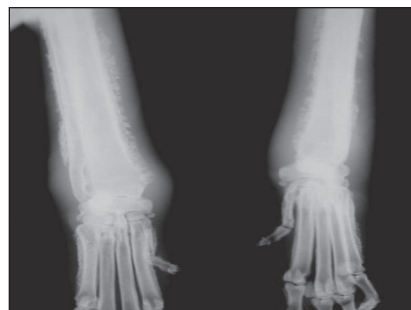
Radiographic view of the thoracic limbs before treatment showing periosteal reaction without underlying bone destruction of the distal portion of radius/ulna.
